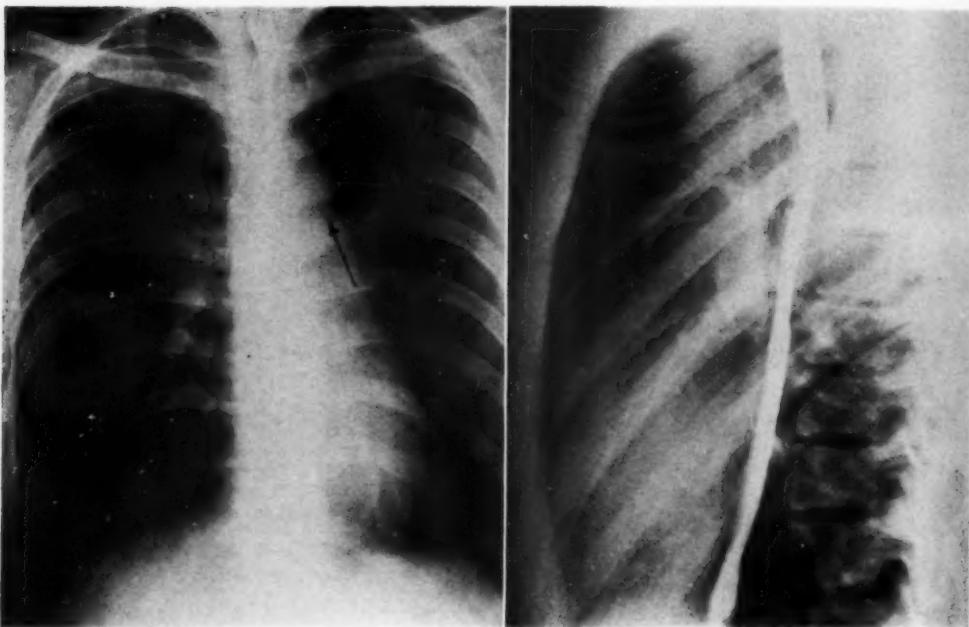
Roentgenograms of chest of twenty-six-year-old male with ductus 10 mm. in diameter, demonstrating "infundibulum sign" and "atypical" cardiac configuration.
